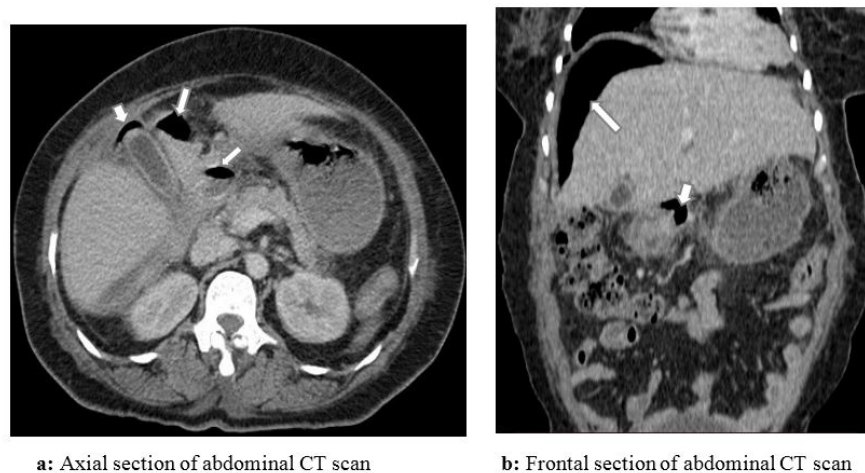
Pneumoperitoneum (arrows) on an abdominal CT of a 69-year-old patient with a gastric perforation.
